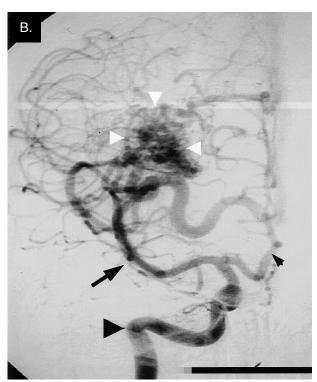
A, Coronal, gadolinium-enhanced magnetic resonance imaging demonstrates a right frontal arteriovenous malformation (AVM) extending to the cortical surface. B, Anterior view of right internal carotid angiogram in the same patient reveals the internal carotid artery (*large arrow head*), the anterior cerebral artery (*small arrow head*), and the middle cerebral artery (*black arrow*). The AVM nidus (*white arrows*) is fed largely by branches of the middle cerebral artery.
